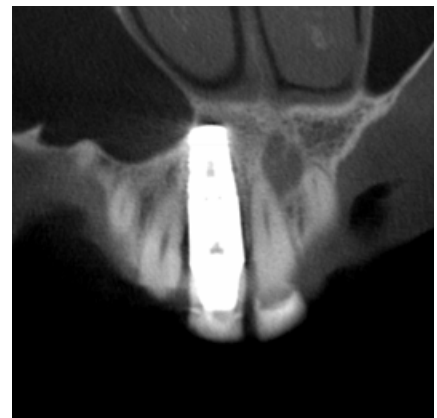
Coronal CBCT slice
